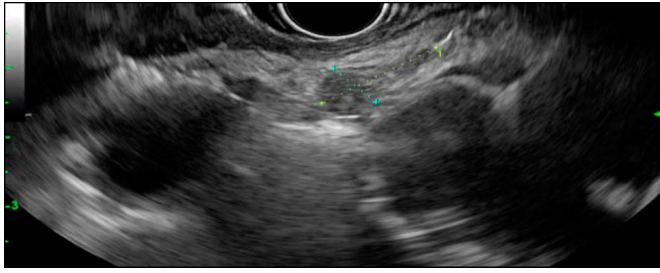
Ill-defined 14 × 7-mm heterogenous lymph node/pancreatic lesion on endoscopic ultrasound examination.
